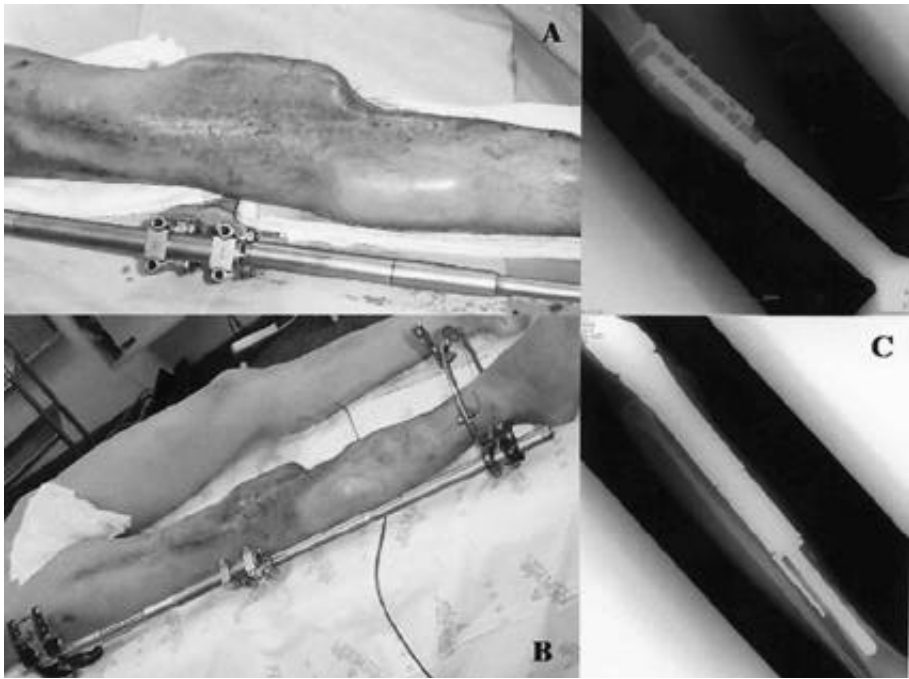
(A) Photographs showed two area of volumetric expansion by concomitant used tissue expander, (B) preoperative state of final operation, and (C) radiographs showed final revision state with tumor prosthesis.
